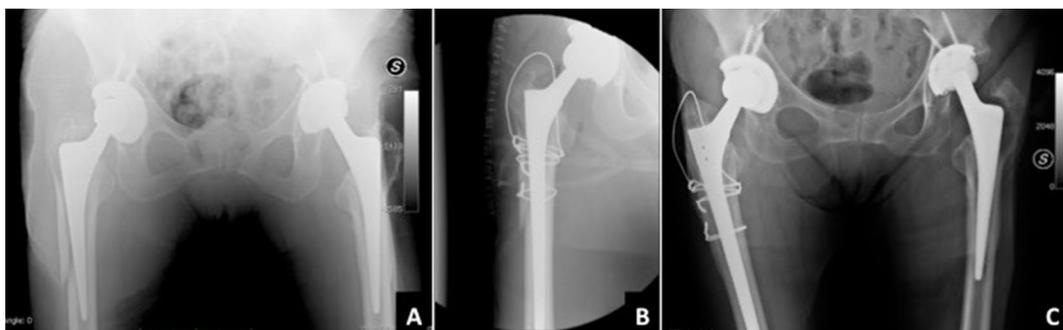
Example of B2 PPFH. a Preoperative AP pelvis X-ray. b Postoperative X-ray showing stem revision and synthesis with cerclage wires. c Three-year follow-up showing excellent radiographic result according to Beal and Tower and very good clinical functional outcome
